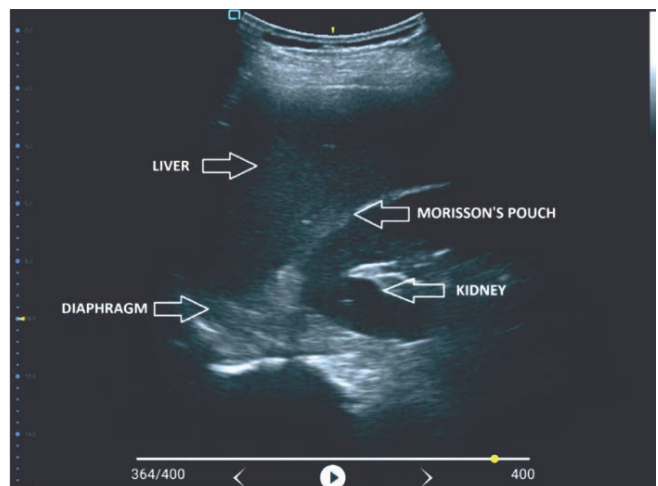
Ultrasound image from Right Upper Quadrant projection
